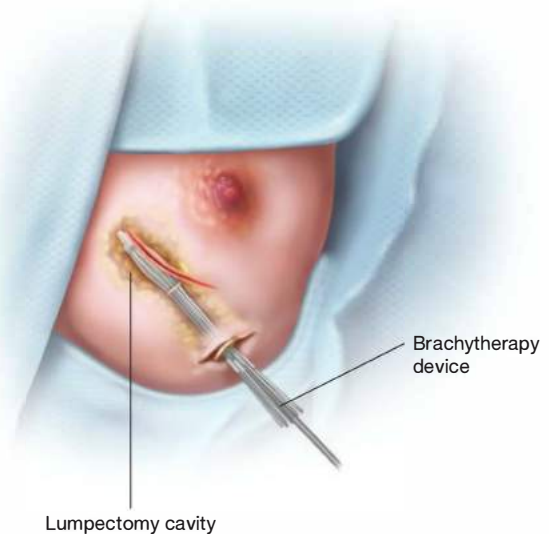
• Exchange of brachytherapy device for CED through same track without need for ultrasound.
